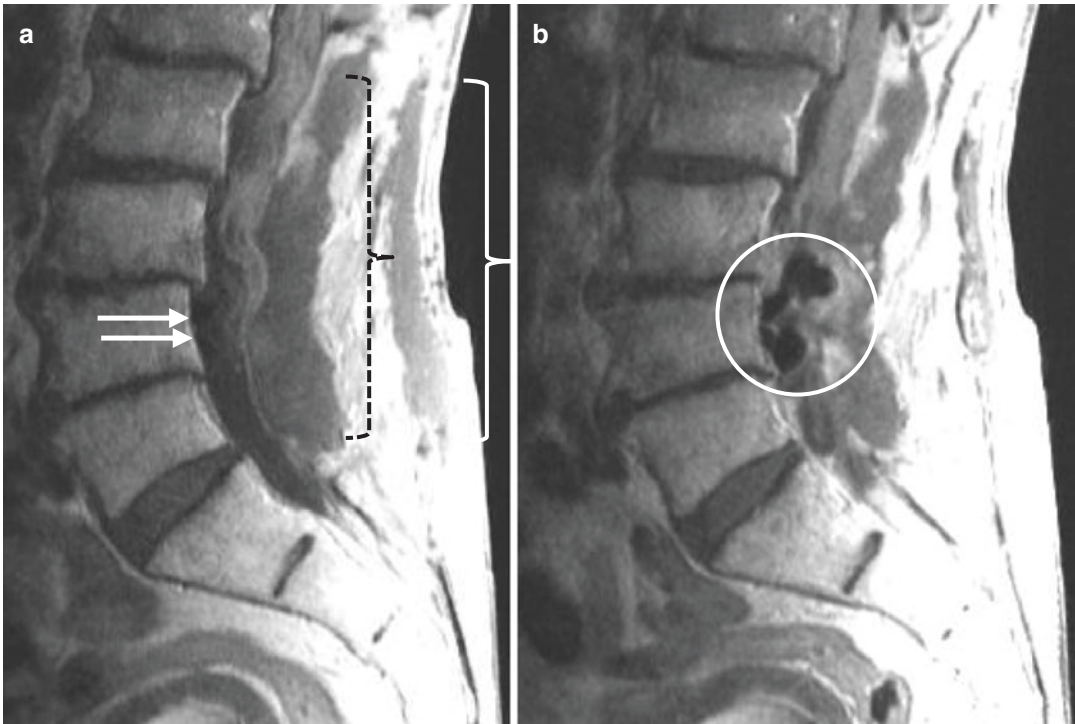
A 82-year-old man with history of prostate cancer and self-catheterization presenting with wound drainage, status post-multilevel laminectomy 1 month prior. Sagittal midline T1-weighted post-contrast MR image (a) demonstrates two large dorsal fluid collections, one superficial (white bracket) and one deep (black
